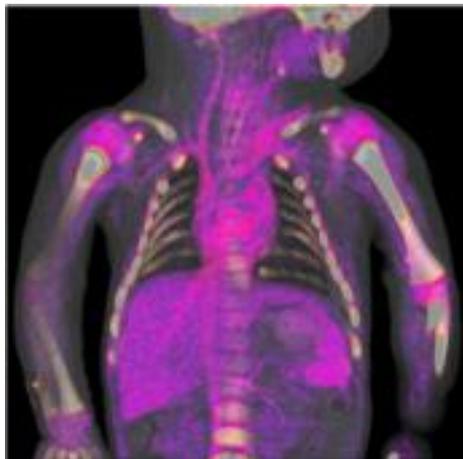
Post-mortem dual energy CT examination of a child. Visualization of hemosiderin (purple color). Great vessels and organ containing blood can be seen without any iodine contrast.
